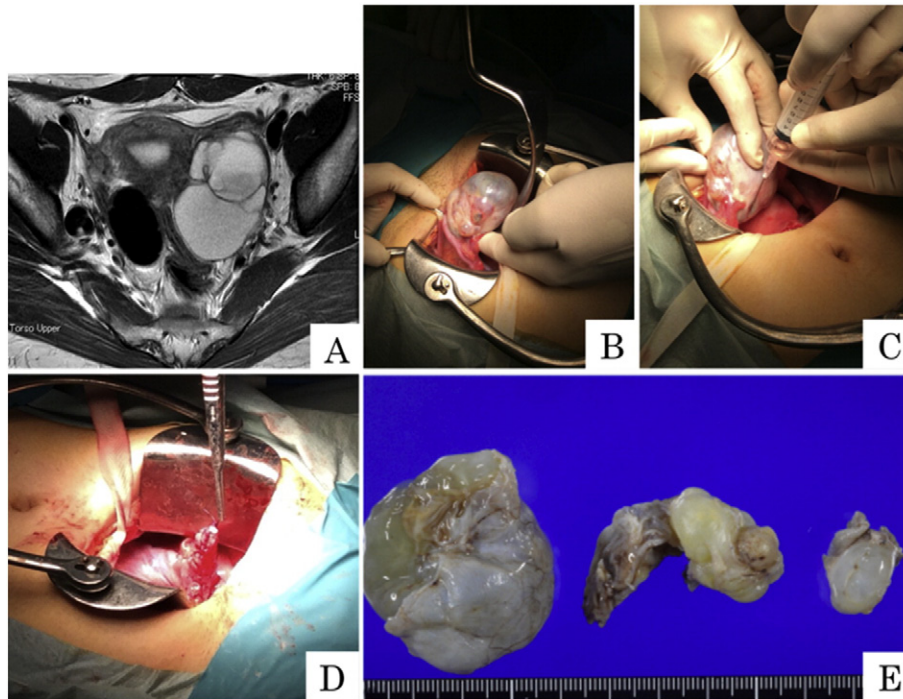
Information on patients and operation. A; Magnetic resonance image before surgery, B; appearance of ovarian cyst, C: aspiration of visible follicles, D; ovary after enucleation, E; tissue of resected ovarian tumor.
